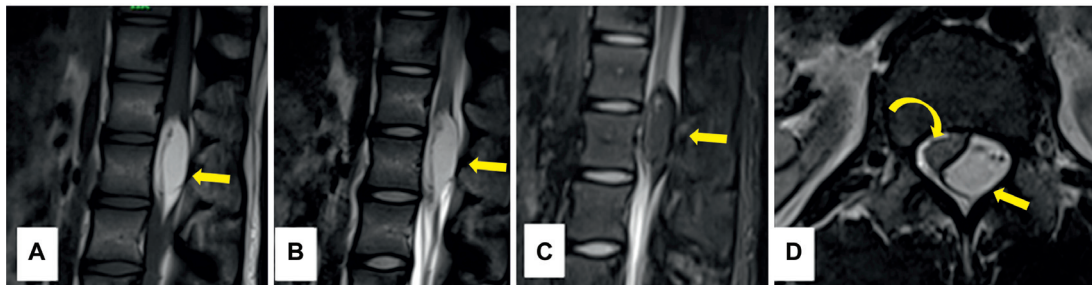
Sagittal T1 (A), T2 (B), and short tau inversion recovery (STIR) (C) images showing dorsal intradural lipoma (arrows) at T12-L1 level, measuring 49 × 20mm, hyperintense on T1, T2-weighted images, hypointense on STIR images. Axial T2 (D) image—cord displaced by lesion (curved arrow) without myelomalacia.
